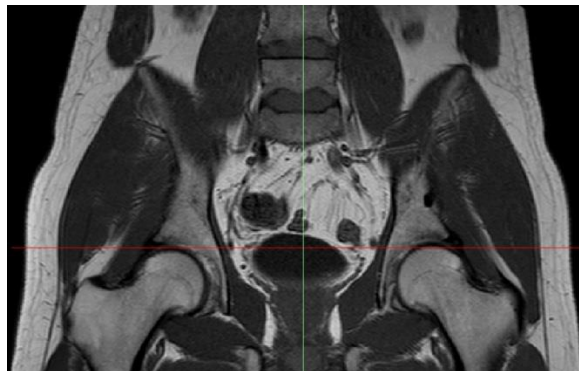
One slice of MR image of pelvis in Atatürk Research and Education Hospital Department of Radiology (data belongs to subject AB).
